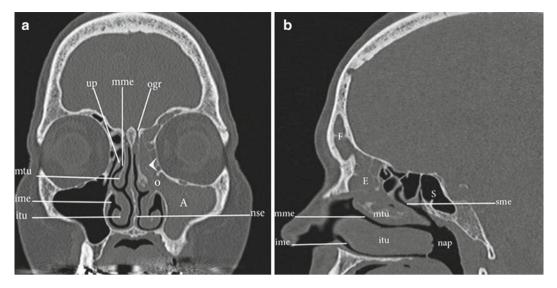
Osteomeatal complex obstruction. Coronal CT with bone window (a) demonstrates a left osteomeatal complex obstructive pattern of sinus opacification; arrow points to the demineralized uncinate process; the maxillary antrum (A) and ostium (o) are opacified. Sagittal reconstruction (b) demonstrates opacification of the frontal sinus (F)
